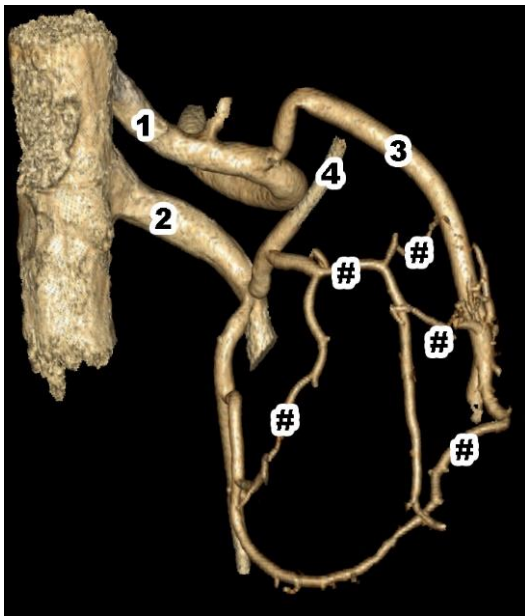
Five pancreaticoduodenal arches. 3D CT reconstruction. [28]
